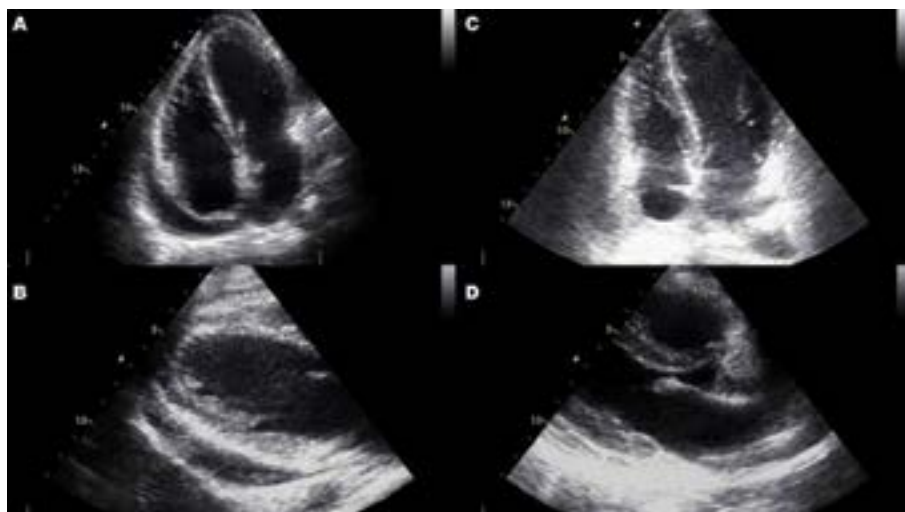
Transthoracic echocardiography: A, B. Echocardiographic findings before implementation of steroid therapy: 1.1–1.5 cm of pericardial effusion with features of fibrin and right atrial collapse; C, D. Regression of pericardial effusion at discharge
